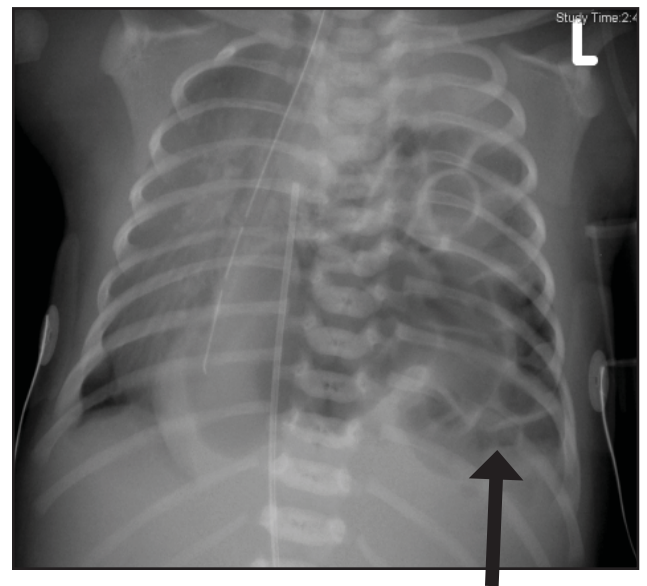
Chest X-ray of patient with left-sided CDH. Arrow points to the stomach and intestine in the left chest cavity.
